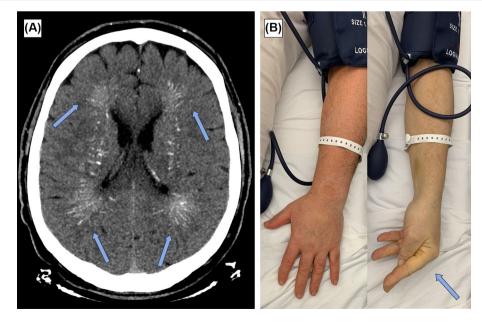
Brain computed tomography (CT) and Trousseau's sign. The figure shows the brain CT findings consistent with Fahr's syndrome (Panel A) and Trousseau's sign (Panel B).
